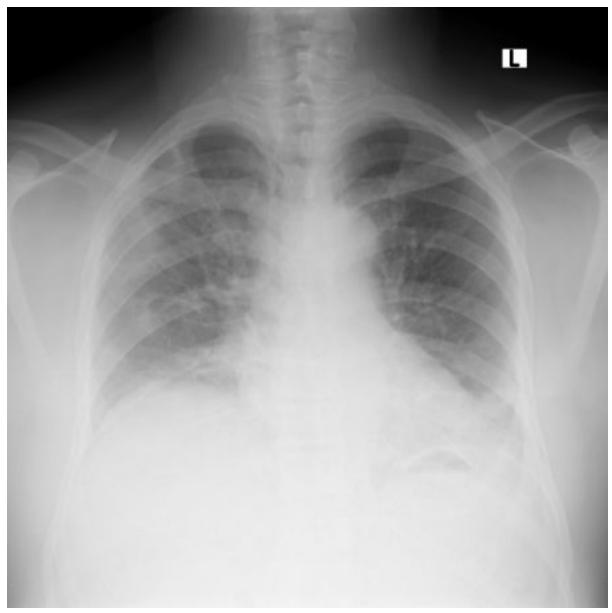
Chest X-Rays Report (23 June 2020): Bilateral patchy and striated groundglass opacity more prominent right lung and left lower lobe. Bilateral lower lobe atelectasis.
